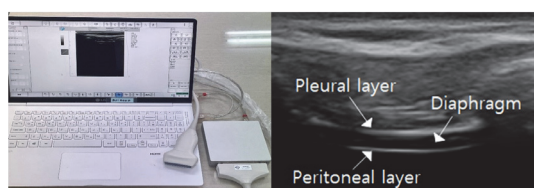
Evaluation of diaphragmatic thickness. (A) Ultrasonography device (MicrUs EXT-1H, Teleded UAB, Lithuania), (B) B-mode ultrasonography image of diaphragm thickness.
